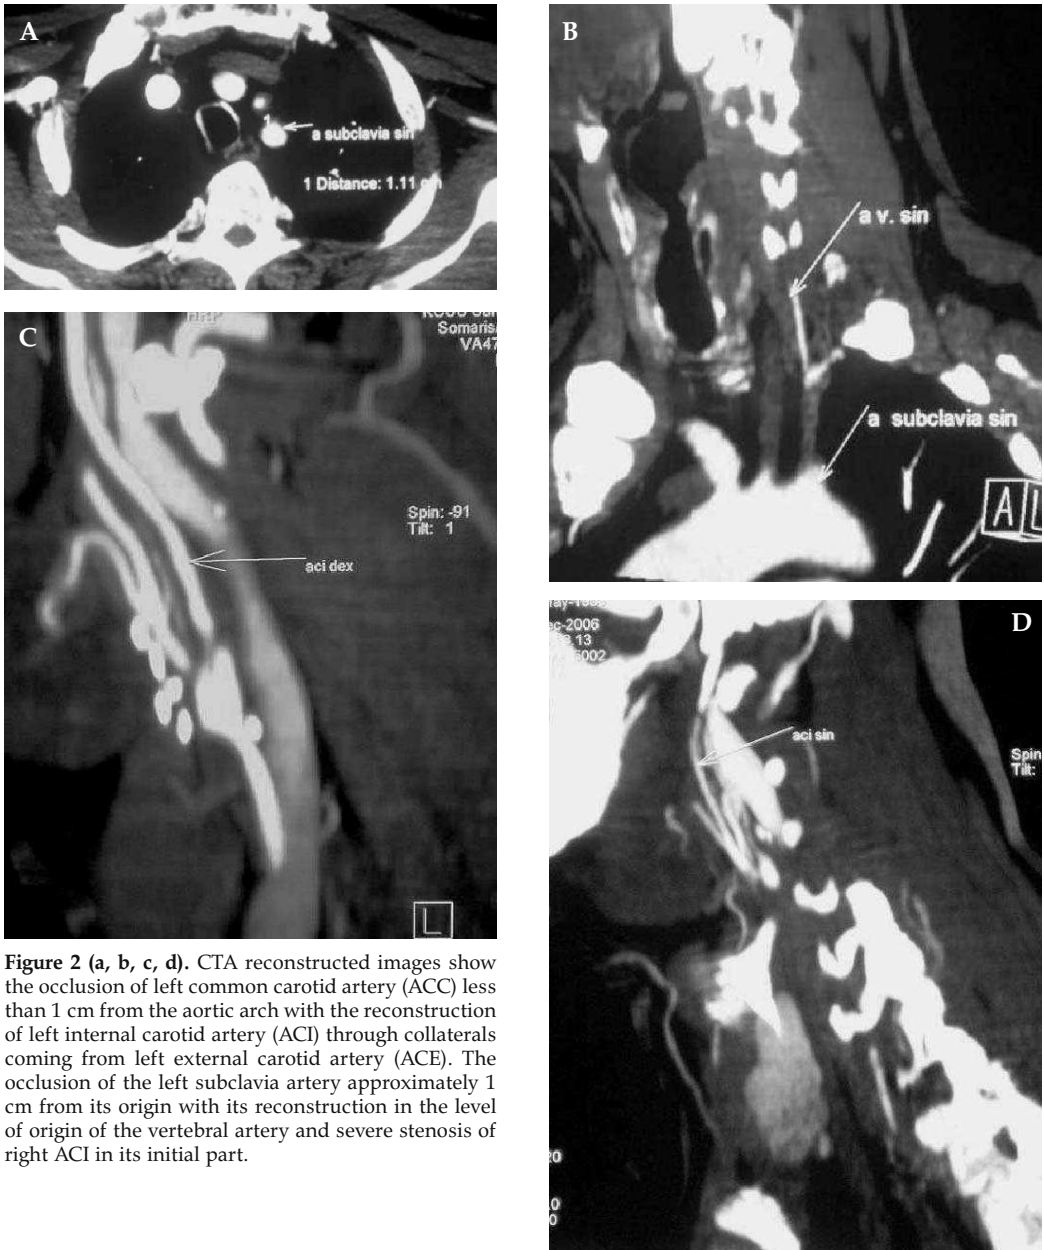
(a, b, c, d). CTA reconstructed images show the occlusion of left common carotid artery (ACC) less than 1 cm from the aortic arch with the reconstruction of left internal carotid artery (ACI) through collaterals coming from left external carotid artery (ACE). The occlusion of the left subclavia artery approximately 1 cm from its origin with its reconstruction in the level of origin of the vertebral artery and severe stenosis of right ACI in its initial part.
